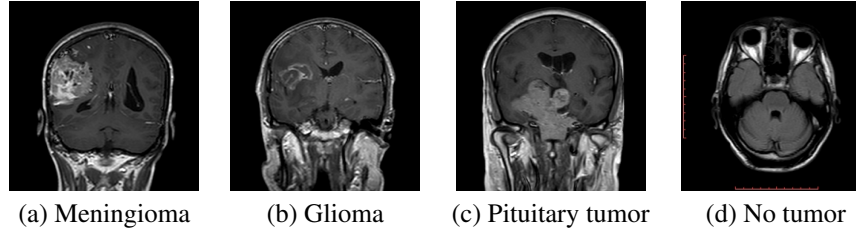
Sample of coronal MRI from the dataset: (a) Meningioma, (b) Glioma, (c) Pituitary tumor, (d) No tumor.
